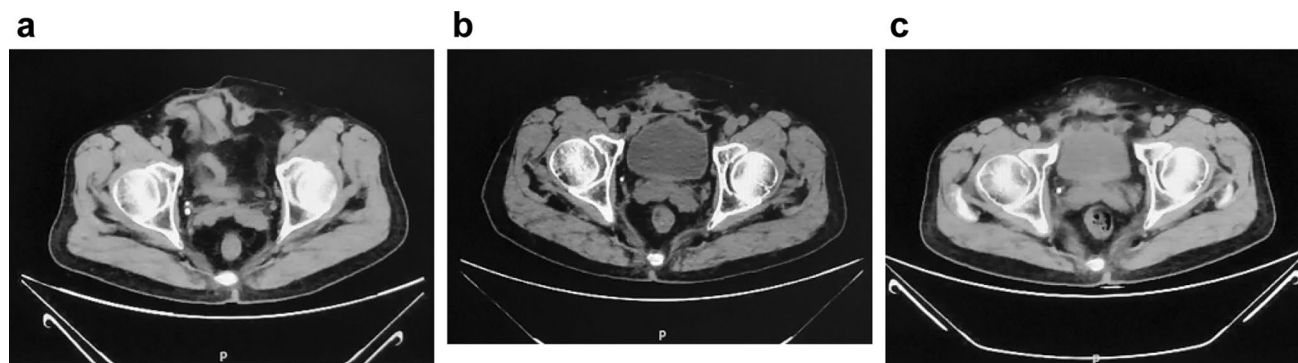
CT images of the abdominal cross-section of one patient before and after surgery. a Before surgery. b Three months after surgery. c Eight months after surgery
